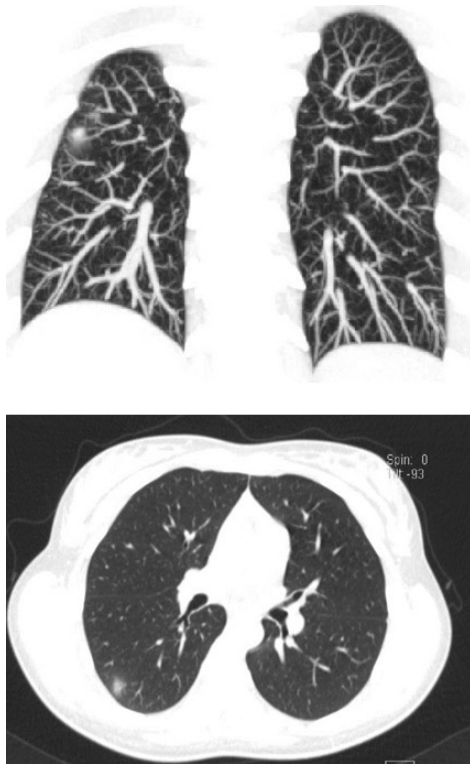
ŞEKİL 1 Figure 1 Thorax Computed Tomographic Image of Coronal and Axial Section Nodular opacity on the periphery of the right sided lung
